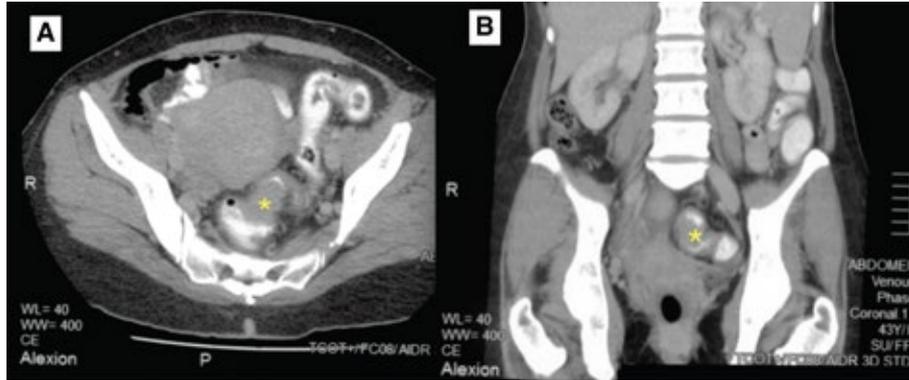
Axial (A) and coronal (B) CT images showed a lobulated soft tissue density mass (*) causing narrowing at the proximal sigmoid colon.
